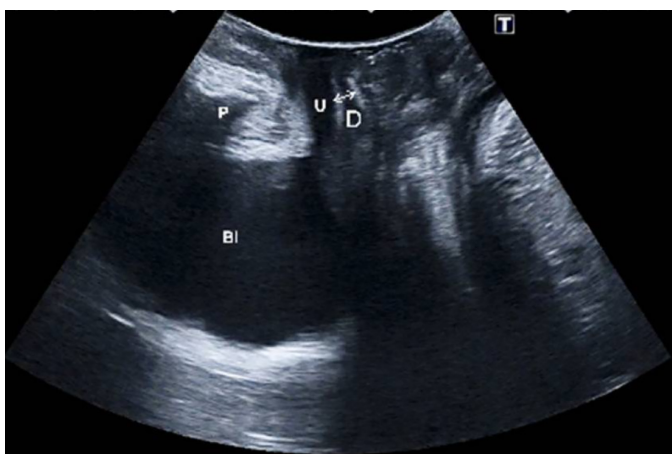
The ultrasound parameters
